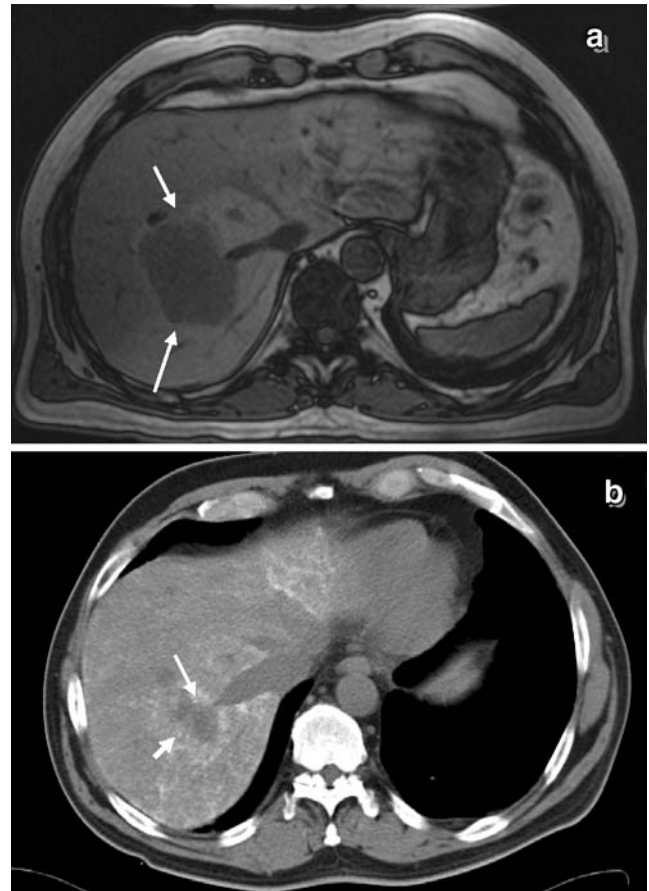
a, b Downsizing of colorectal liver metastases using TACE followed by LITT. a Post-contrast T1-weighted MRI showing a large right hepatic lobe metastatic mass (*arrows*) in a patient with colorectal carcinoma which was not treatable by LITT. b Non-contrast CT showing the same lesion after three TACE sessions with lipiodol retention and size reduction (*arrows*) paving the way for thermal ablation with LITT
